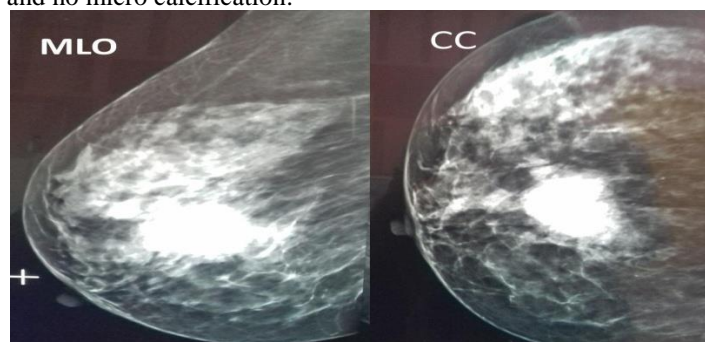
Case 2: mammography of the right breast including craniocaudal (CC) and mediolateral oblique (MLO) views, shows heterogeneous breast density with right side ill-defined high dense lobulated mass and no micro calcification. Figure (5) Ultrasound shows underlying hypo echoic lobulated mass with evidence of internal vascularity, seen opposite 12 o'clock, measuring about 4.5x4 cm.
